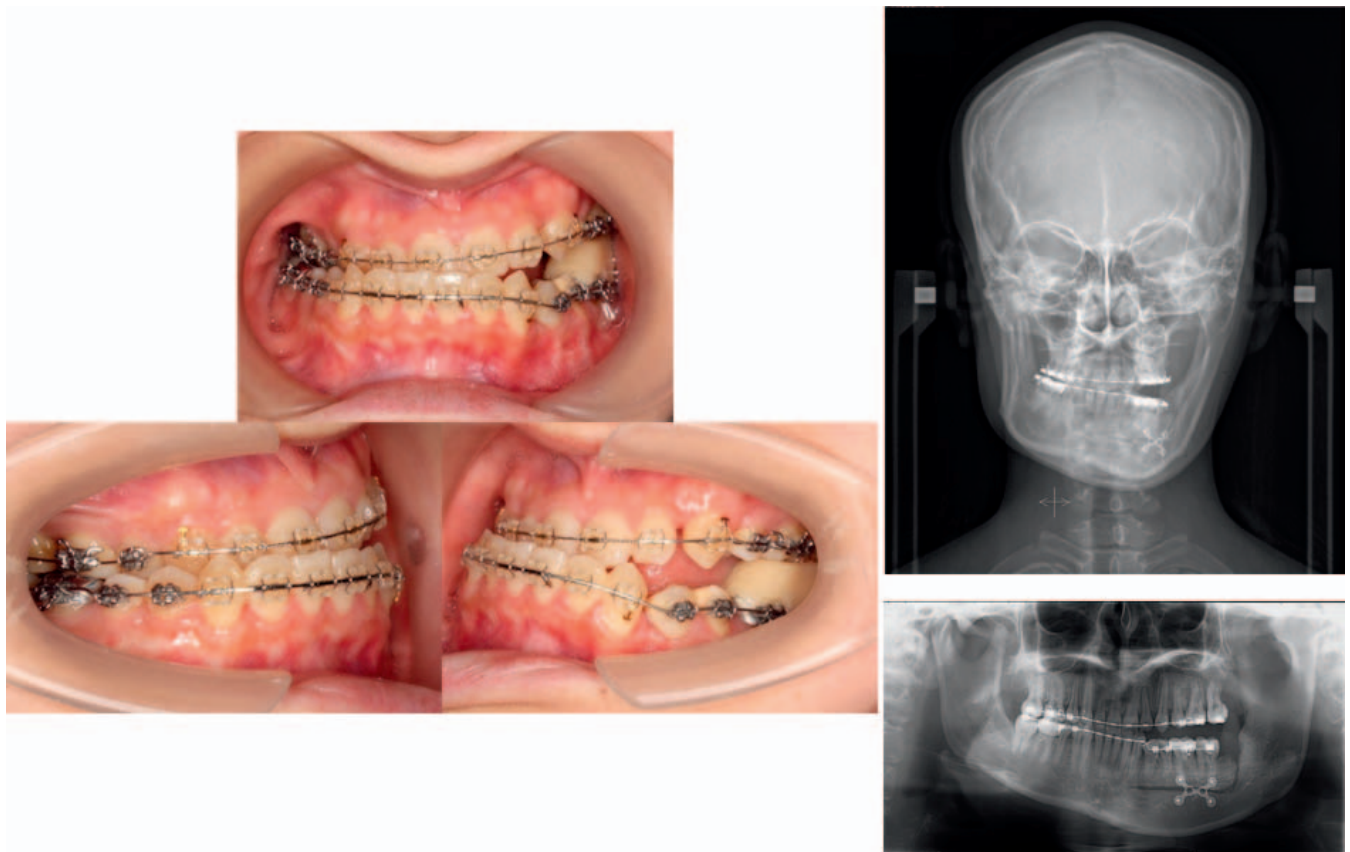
Intraoral photographs and panoramic and cephalometric radiographs obtained after segmental osteotomy are shown.
